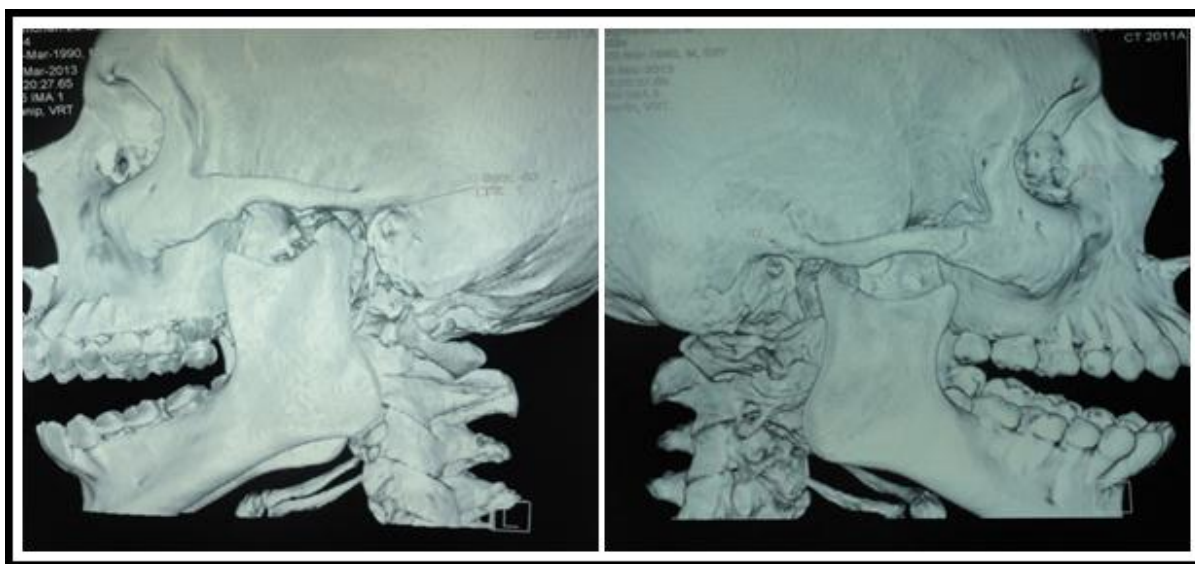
Post eminectomy follow up CT images.
